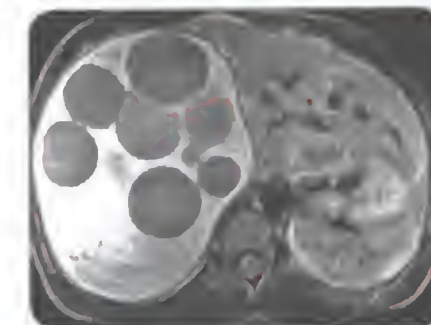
Magnetic resonance image picture of multiple hydatid cyst of liver—MRI is very useful investigation in hydatid cyst of liver
